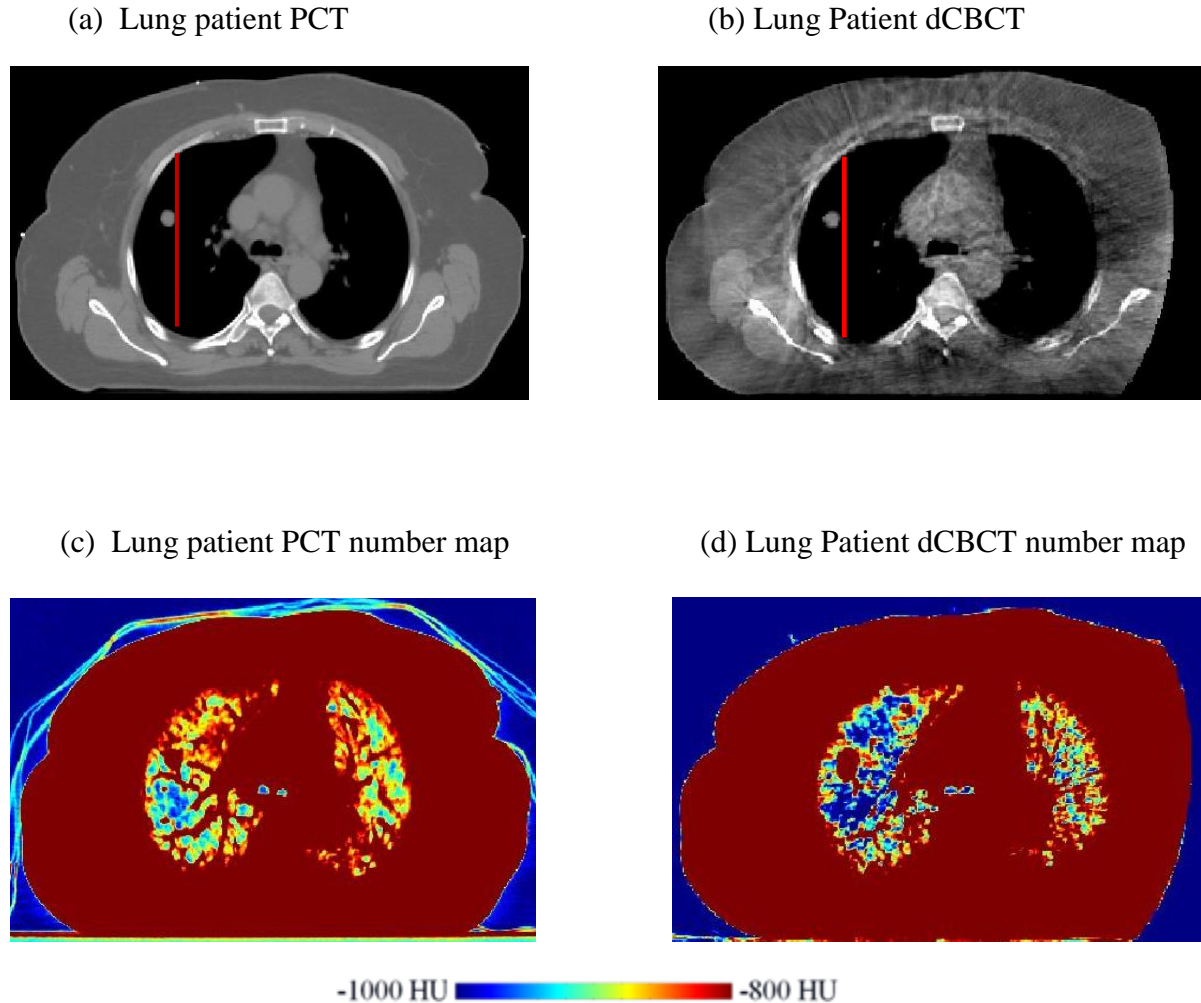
(a) Planning CT (PCT) image and (b) deformed CBCT (dCBCT) image of the lung patient. The red line indicates the image profile region where CT number comparisons were made in subsequent figures. Please note that the profile is within the lung tissue proximal to the tumor. Figs 4-5 (c) and (d) display CT number intensity colour maps of lung tissue within the PCT and dCBCT patient images (level = -900 HU, window = +/- 100 HU). Figure 4-5 (d) shows that dCBCT lung tissue appears much lower in density.
